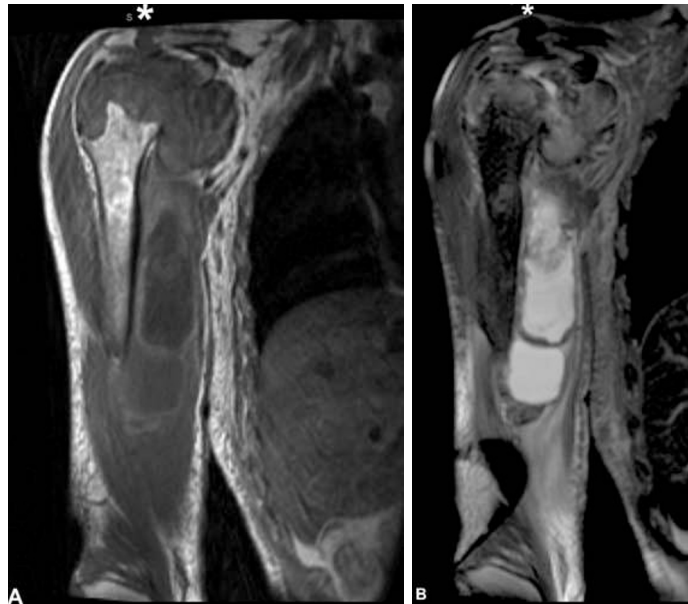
MRI of the right humerus. Coronal T1 (TR 500/TE 13) and coronal T2 (TR 4350 /TE 82) -weighted MR images of the right humerus. Thickened synovium expands the shoulder joint and erodes the humeral head and glenoid fossa (arrow Fig 6b). The tendon sheath of the tendon of the long head of the biceps brachii muscle is distended by cyst-like pockets of fluid.
